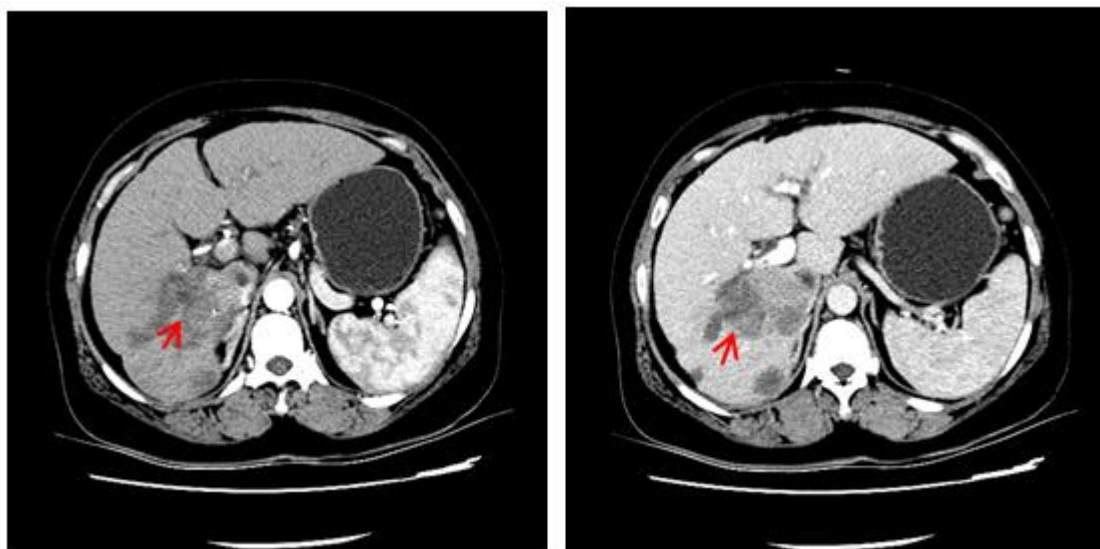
CT Evaluation After Four Cycles of Immunotherapy Combined with Chemotherapy (XELOX) and TACE
